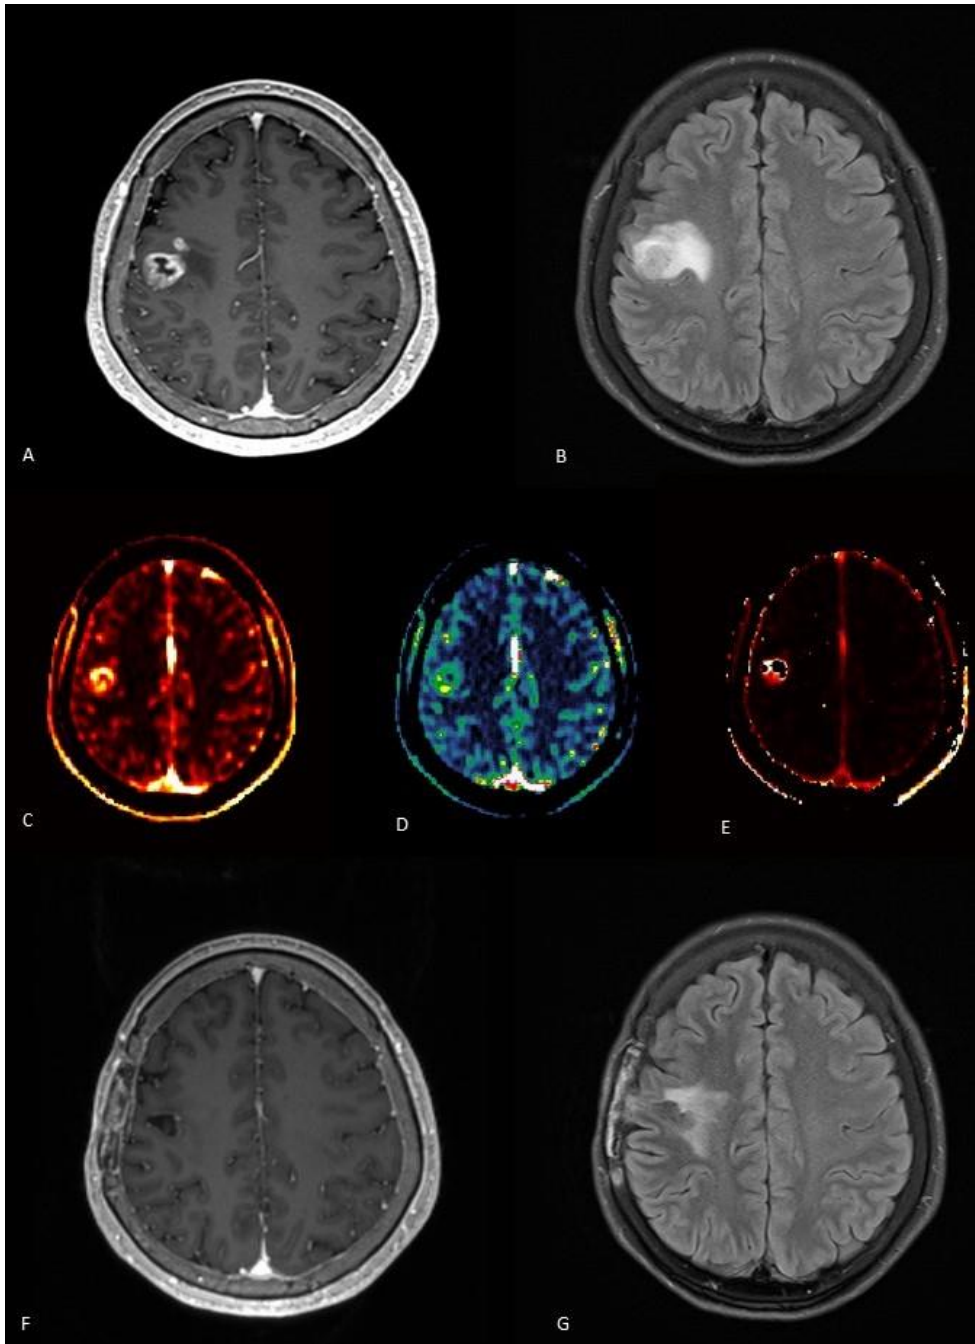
Low-risk patient (radiomics risk score: -0.9367459). A 51-year-old patient with glioblastoma. A preoperative axial MRI demonstrates a contrast-enhanced lesion with perilesional T2 high
